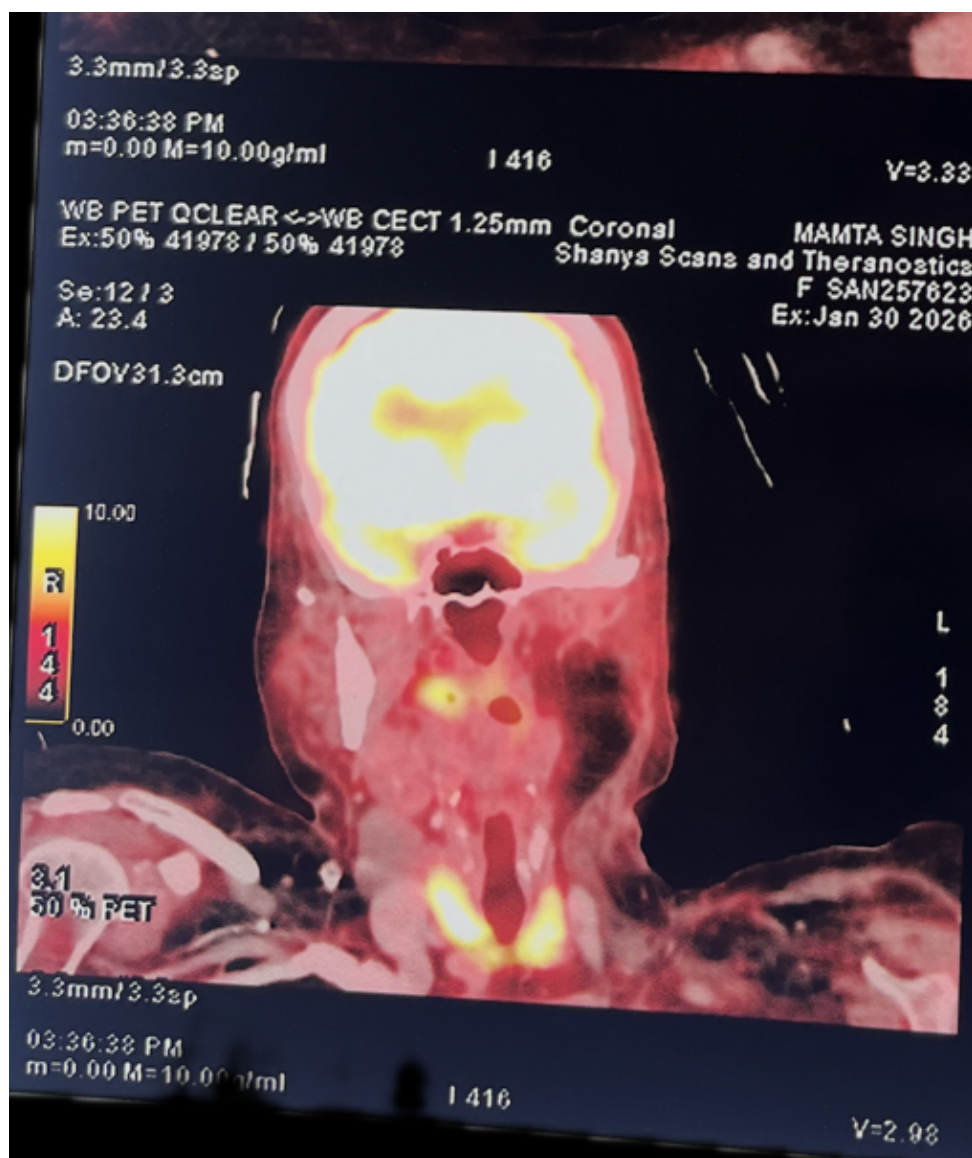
Figure 1A: Coronal Fused PET/CT showing intense diffuse FDG uptake in the thyroid gland ( $\text{SUV}_{\text{max}}$  14.0), mimicking malignancy.
